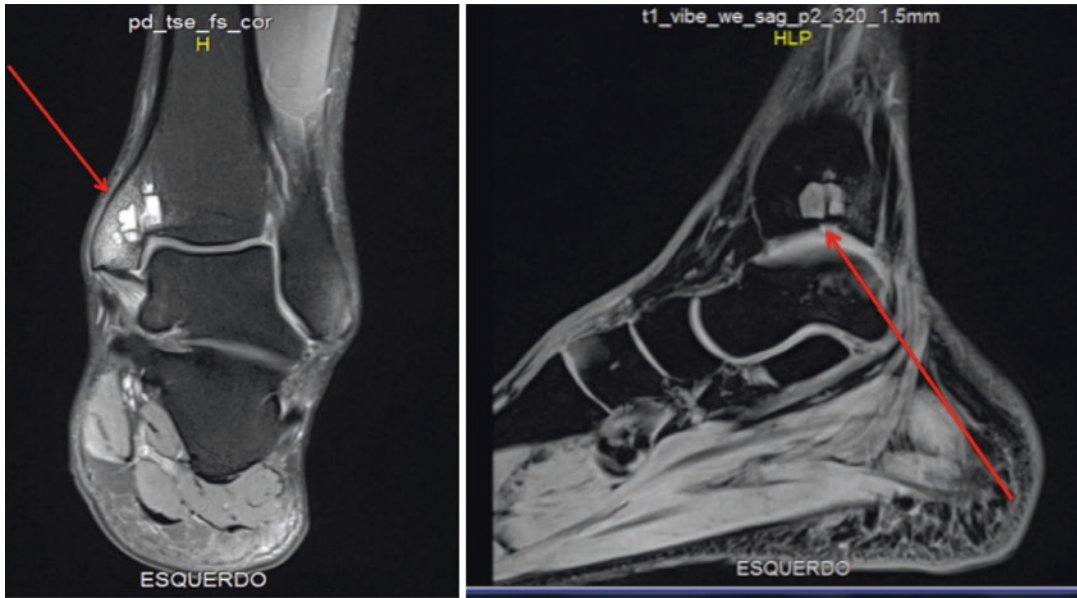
MRI T2 images showing OC defect on the distal tibia with bone cysts formation
